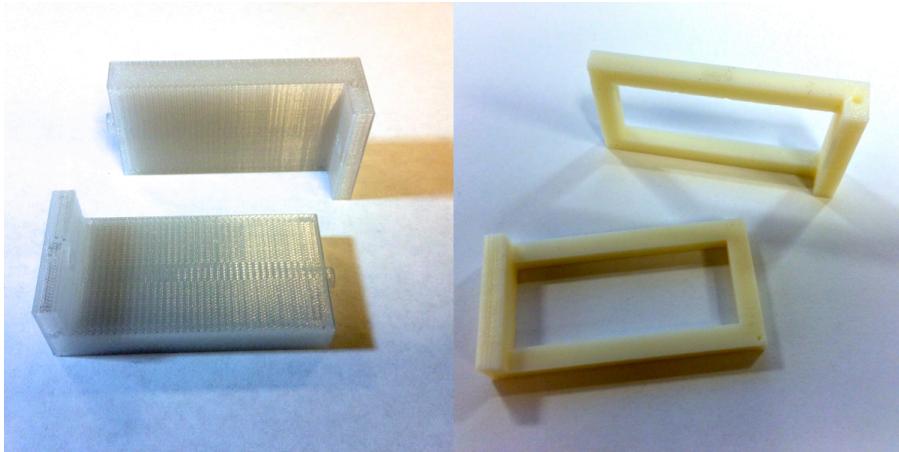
A set of testing apparatus were designed and 3D printed for this study to measure the depth-dose curve for  $^{192}\text{Ir}$ . The apparatus held a piece of radiochromic film and an endobronchial brachytherapy catheter. The left picture shows the testing apparatus printed in PC-ISO, and the picture on the right shows control apparatus used to suspend a piece of radiochromic film in water. The apparatus were scanned in a helical CT to compute the Hounsfield unit distribution.
